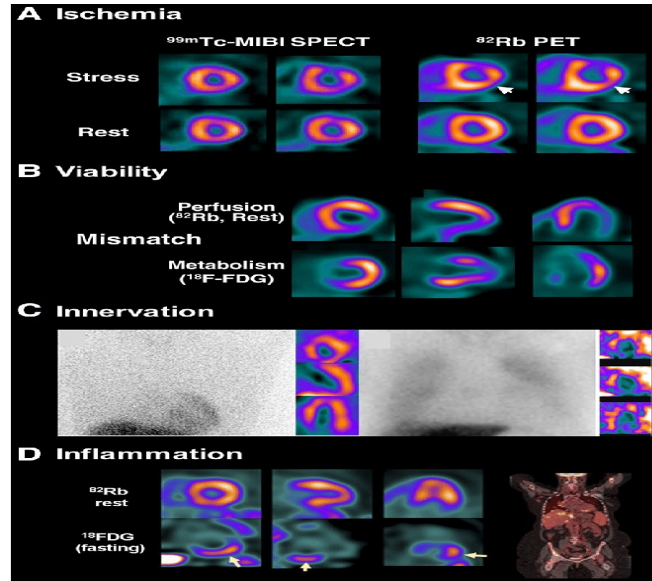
The many faces of nuclear cardiology in heart failure. (A) Perfusion imaging for detection of ischemia. Comparison of SPECT and PET (B) Imaging of myocardial viability. Perfusion/metabolism mismatch indicating hibernating myocardium (C) Imaging of sympathetic innervation. Shown are planar and SPECT images in a patient with preserved (left) and impaired (right) innervation. (D) Imaging of myocardial inflammation in sarcoidosis
